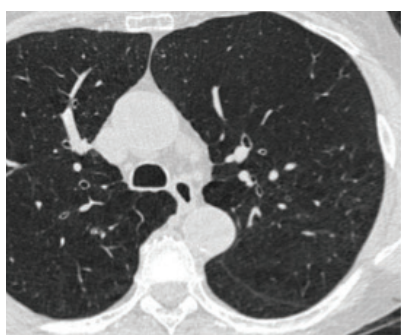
Axial HRCT images at the level of upper lobes. a) Pre-procedural CT showing severe emphysema in both upper lobes. b) Partial collapse of the left upper lobe at 24 hours after EBV placement. c) Complete collapse of the left upper lobe at 30 days with EBVs in situ. Mediastinal shift towards left due to volume loss.
